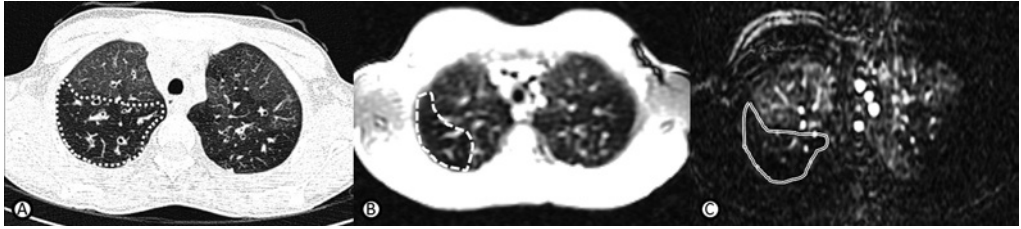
Comparison between CT, MRI and CEMRI. (A) End-expiratory axial CT, (B) end-expiratory axial 2D Steady-State Free Precession (SSFP) proton-MRI and (C) axial end-expiratory reformat 3D Spoiled Gradient Echo (SPGR) with TRICKS contrast-enhanced MRI. Note that the hypodense area in image A (dotted area) is larger than the hypointense area in B (dashed line), and similar to the hypointense area in C (double line).
